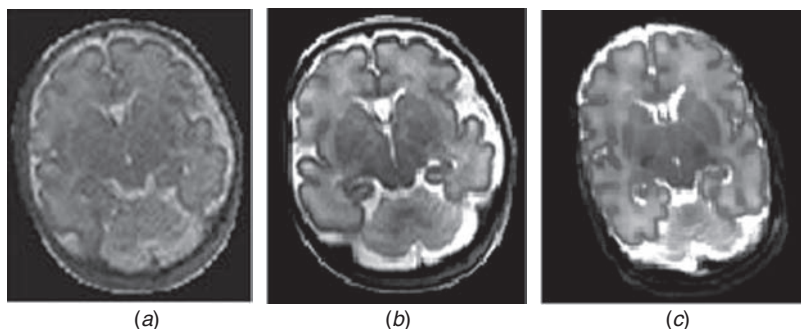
Fetus of 33 weeks' gestation. Single-shot, T2-weighted image dynamically acquired at 1.5T in the (a) coronal plane post acquisition and (b) post registration by computer program of four loops of data (Jiang *et al.*, 2007). The registered image shows high signal-to-noise and high resolution comparing favorably with a postnatal image acquired at 3T in an infant of similar postmenstrual age (c).
